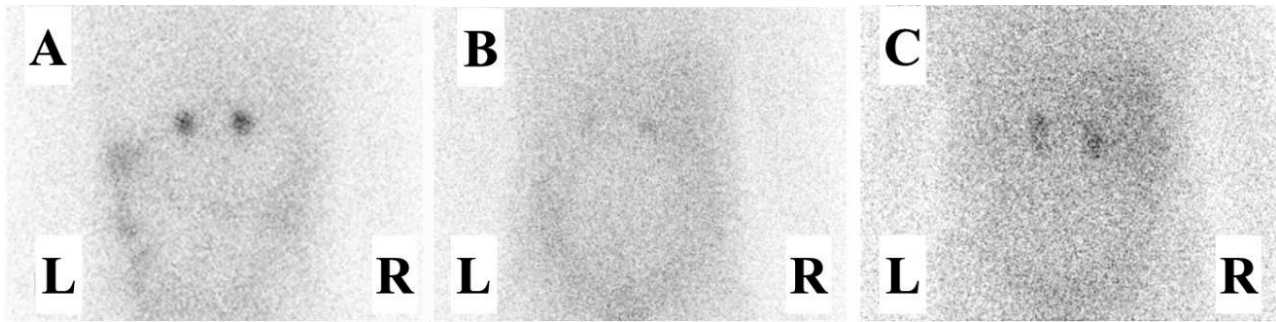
Adrenal scintigraphies of bilateral adrenal tumors. Each adrenal scintigraphy using ^{131}I -adosterol showed bilateral uptake of the tracer (A: case 1, B: case 2, C: case 3).
